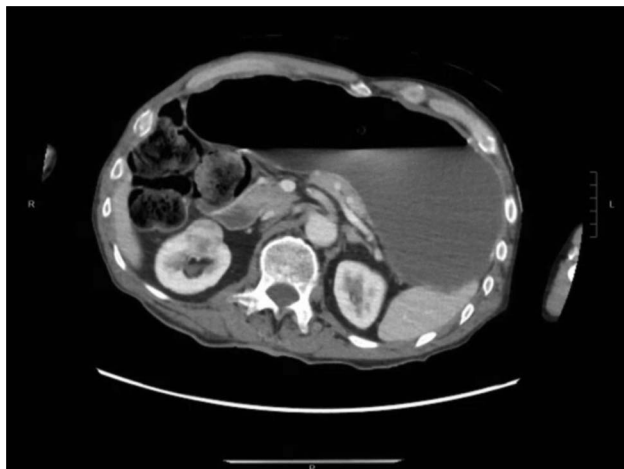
Computed tomography of the abdomen revealing markedly distended and fluid filled stomach.
